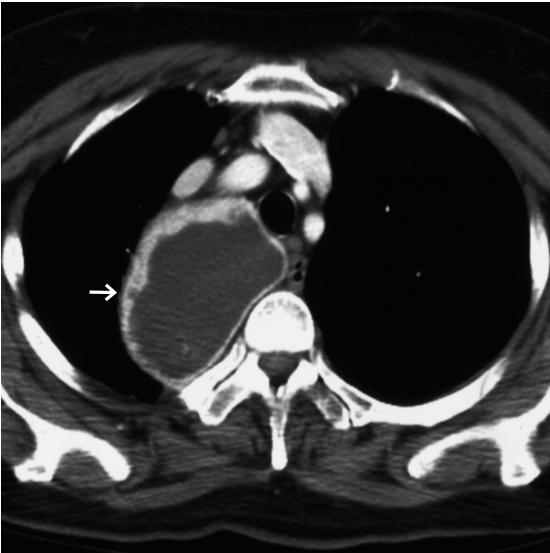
CECT of the thorax (same patient as above image) shows mediastinal extension of the large thyroid nodule (→). CT/MRI are useful in evaluating retrosternal, mediastinal extension of thyroid lesions.
